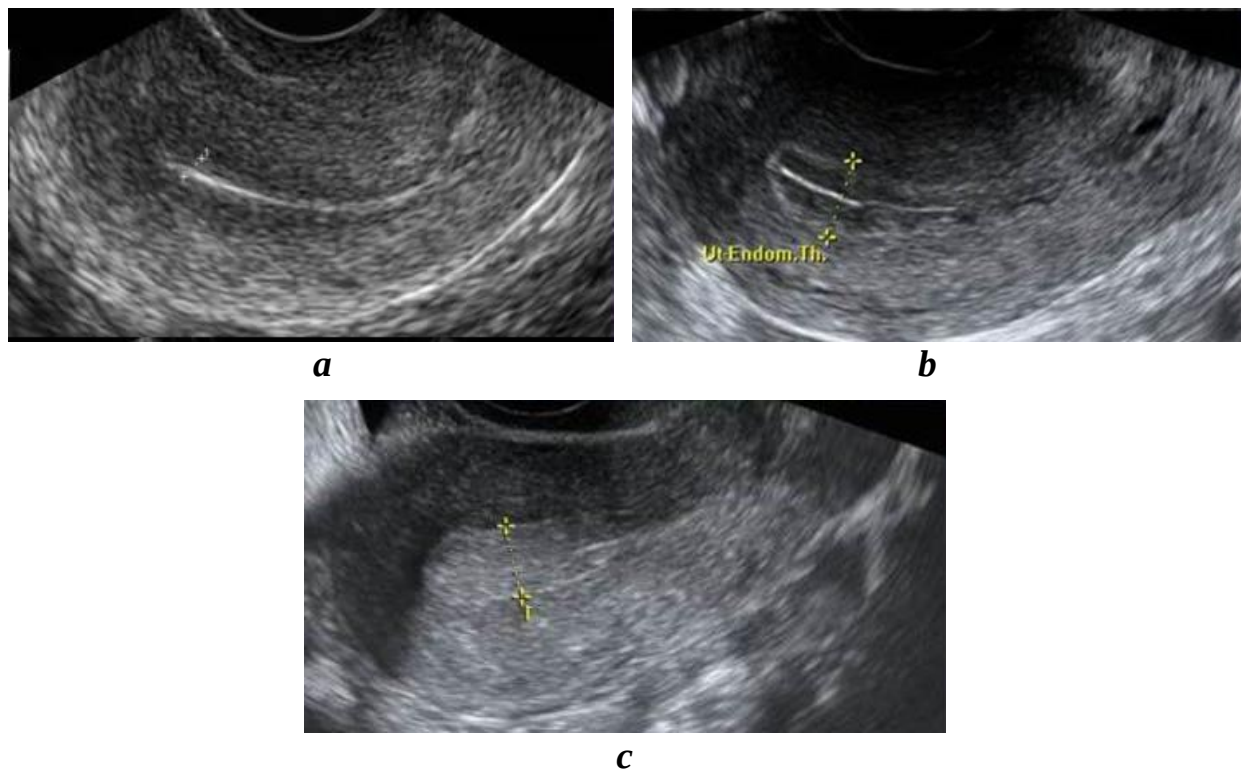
Types of endometrium in transvaginal ultrasound
